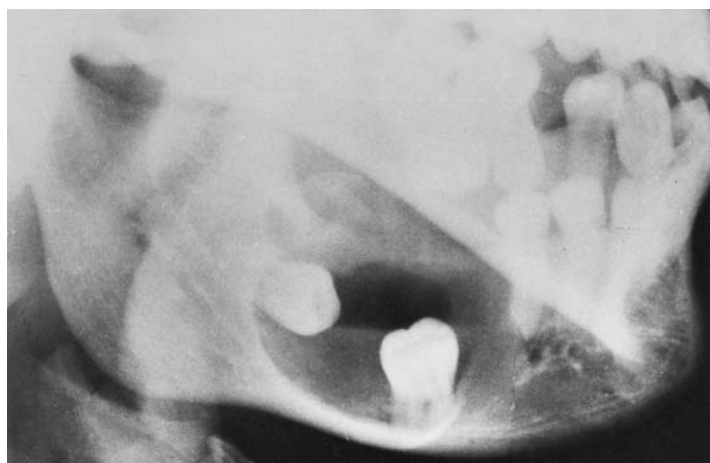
Radiograph of a unilocular ameloblastoma that appears to be a dentigerous cyst.
